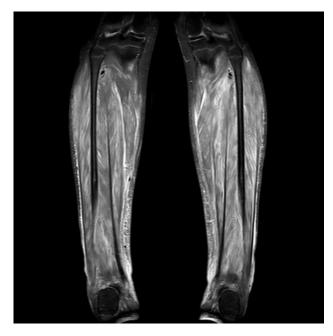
T2-weighted MRI lower extremities coronal view
